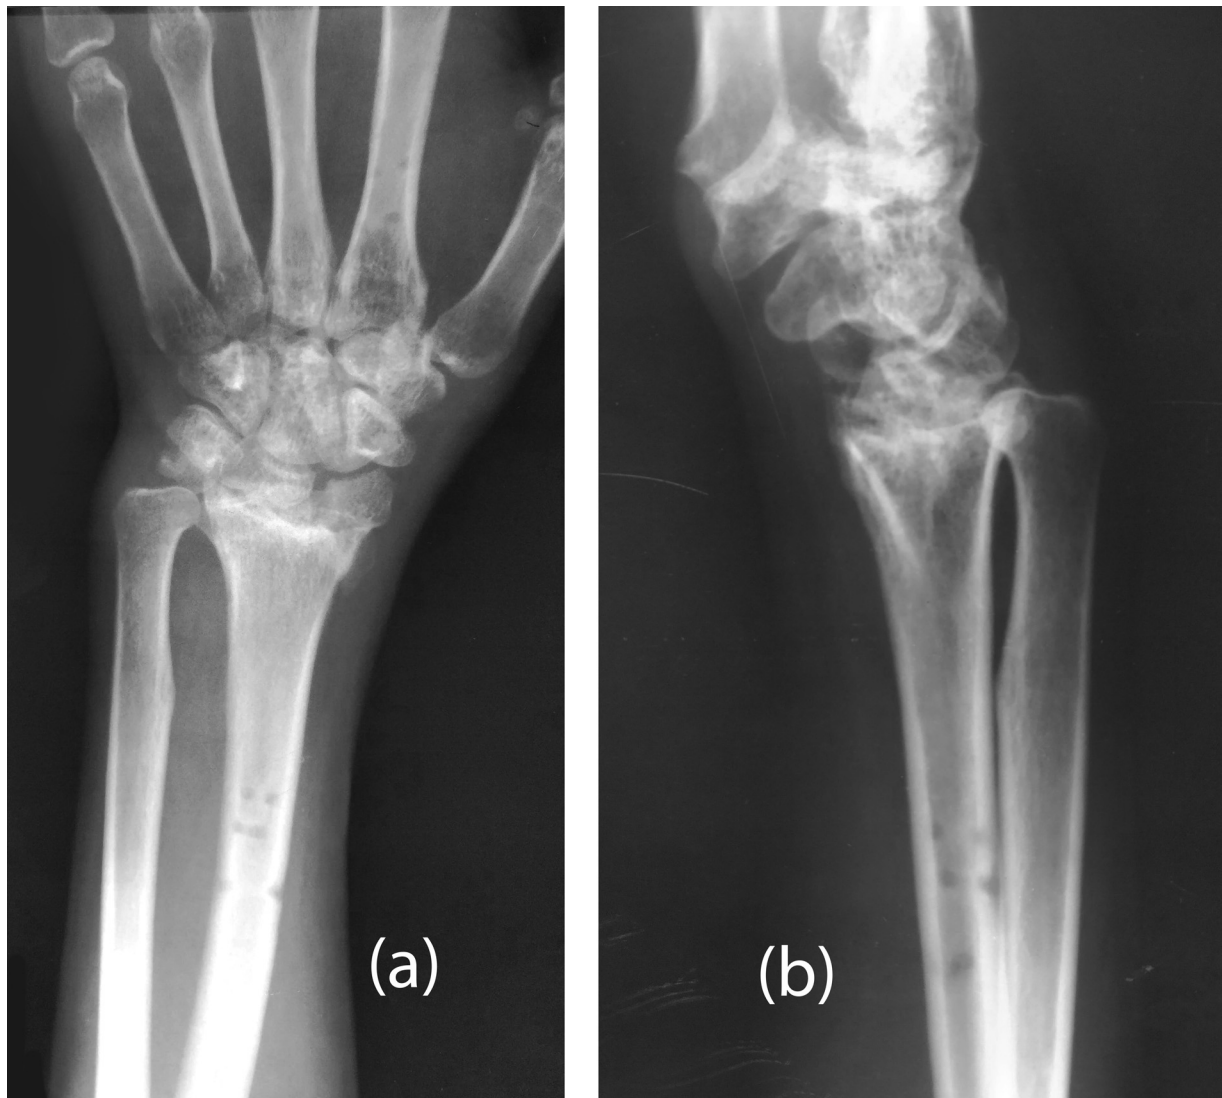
Preoperative X-ray of the Wrist (PA and lateral views).
